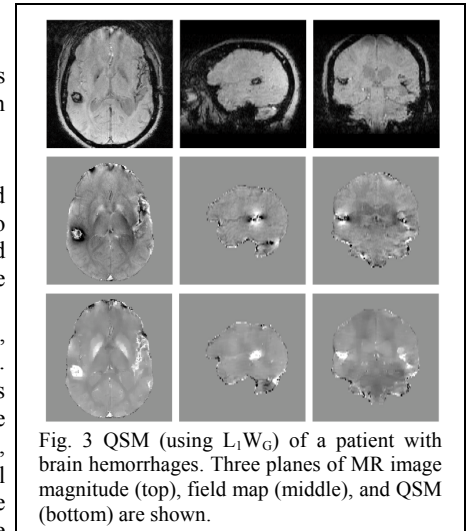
QSM (using  $L_1 W_G$ ) of a patient with brain hemorrhages. Three planes of MR image magnitude (top), field map (middle), and QSM (bottom) are shown.
